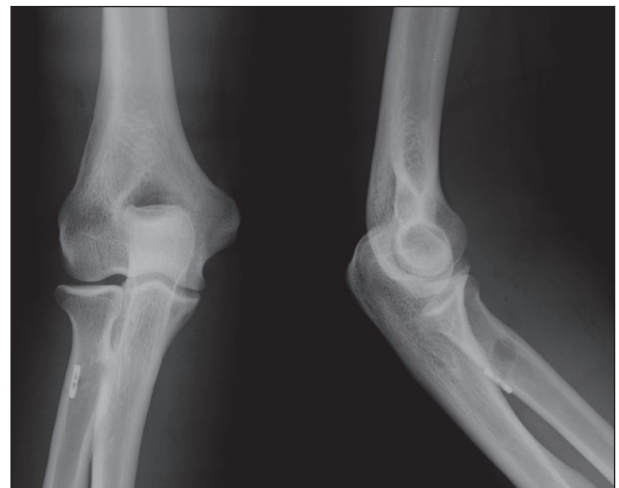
X-ray control at the final follow-up
